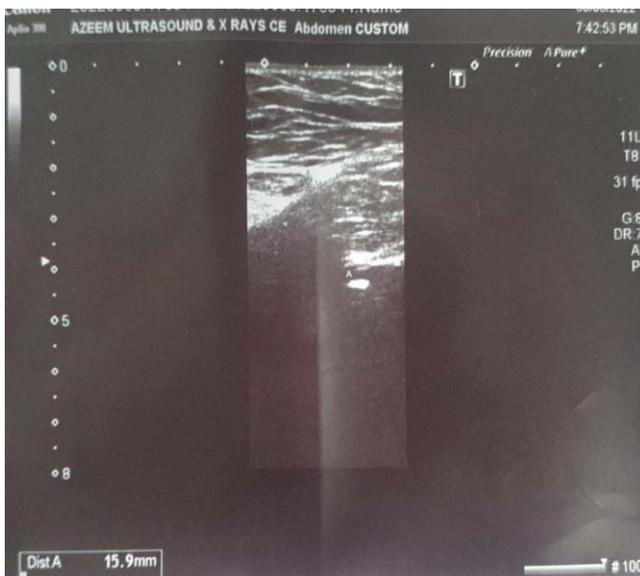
Showing Inguinal hernia on ultrasound
